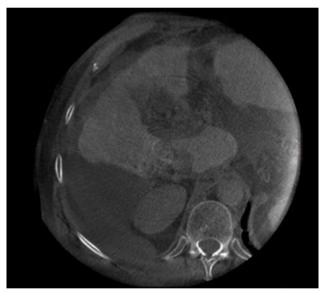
Dual-phase CBCT of second session demonstrated devascularization of the nodule by means of a reduction in the attenuation values – Delayed phase 3 mm MP
